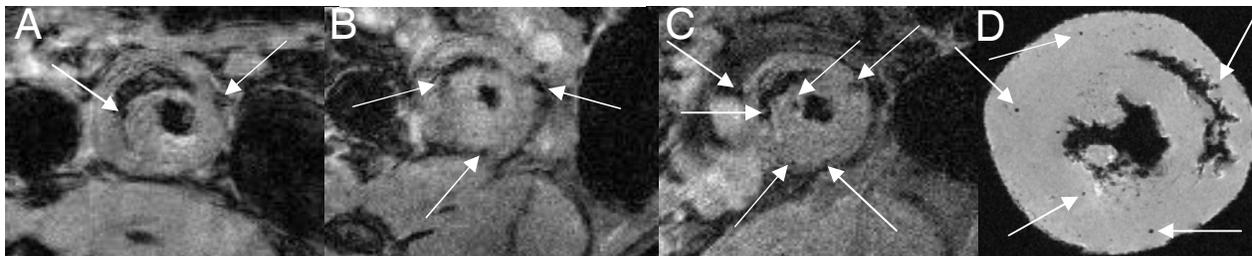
T2*-weighted *in vivo* MRI for an allograft on POD 7 (A), POD 14 (B) and POD 20 (C) after MPIO labeling. Few but very sparse punctate and distinct contrast spots can be seen and confirmed by MRM (D), as indicated with arrowheads, which represent MPIO labeled immune cells, mainly macrophages.
